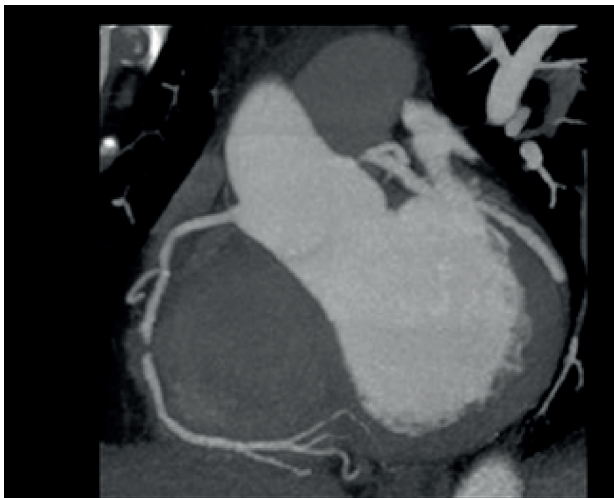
Patient with acute chest pain. Coronary computed tomography angiography showing severe obstruction in the middle third of the right coronary artery (arrows).
